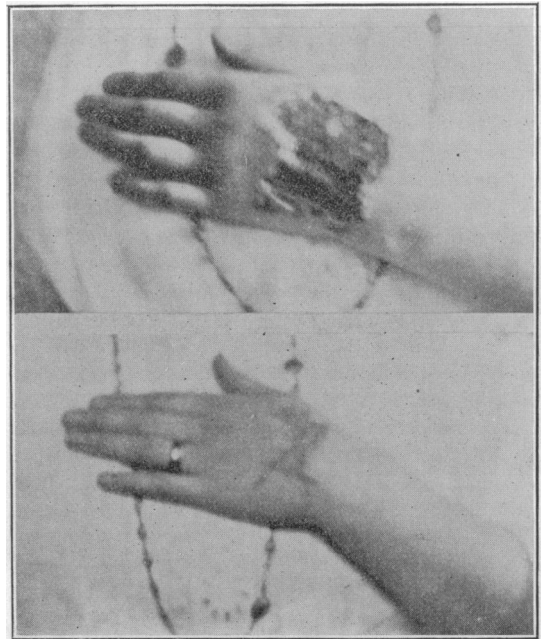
Tubercular Ulcer of Hand before and after X-Ray application.
